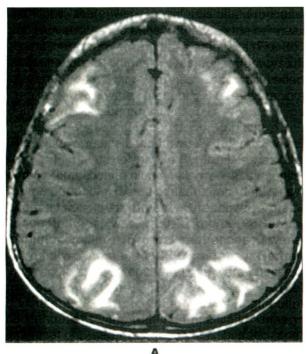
Sagittal FLAIR image (TR: 7000, TE: 110, TI:2000) shows high signal intensities in the fronto-parieto-occipital lobes, representing vasogenic edema (A). Follow-up sagittal FLAIR image after 7 days reveals the disappearance of the lesions in the frontal lobes and significant reduction in size and signal intensity of the lesions in the parietal and temporal lobes (B).
